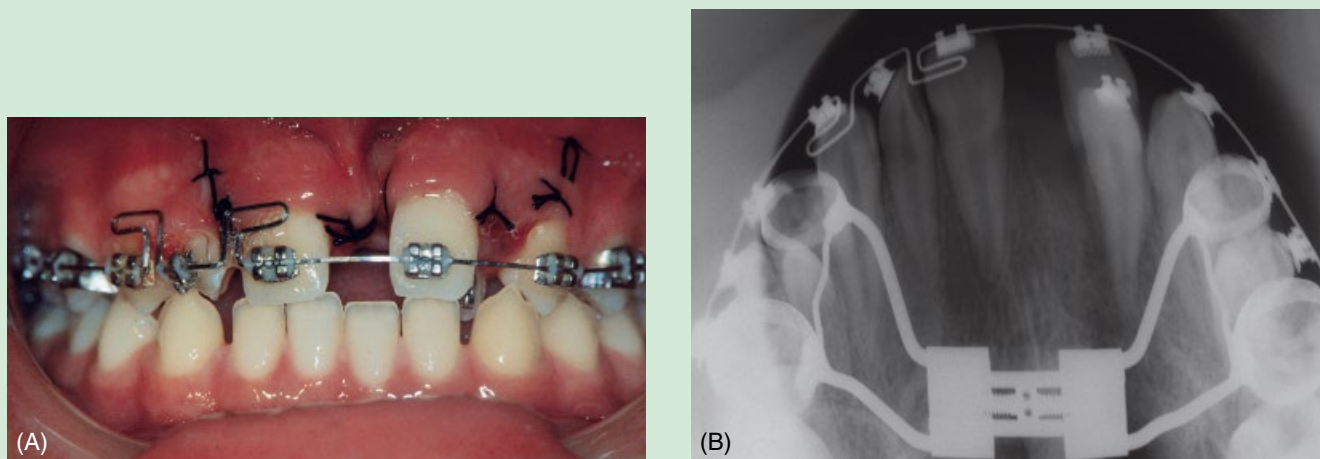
Immediately after surgery a rapid palate expander is placed (A). Control X-ray (B).
